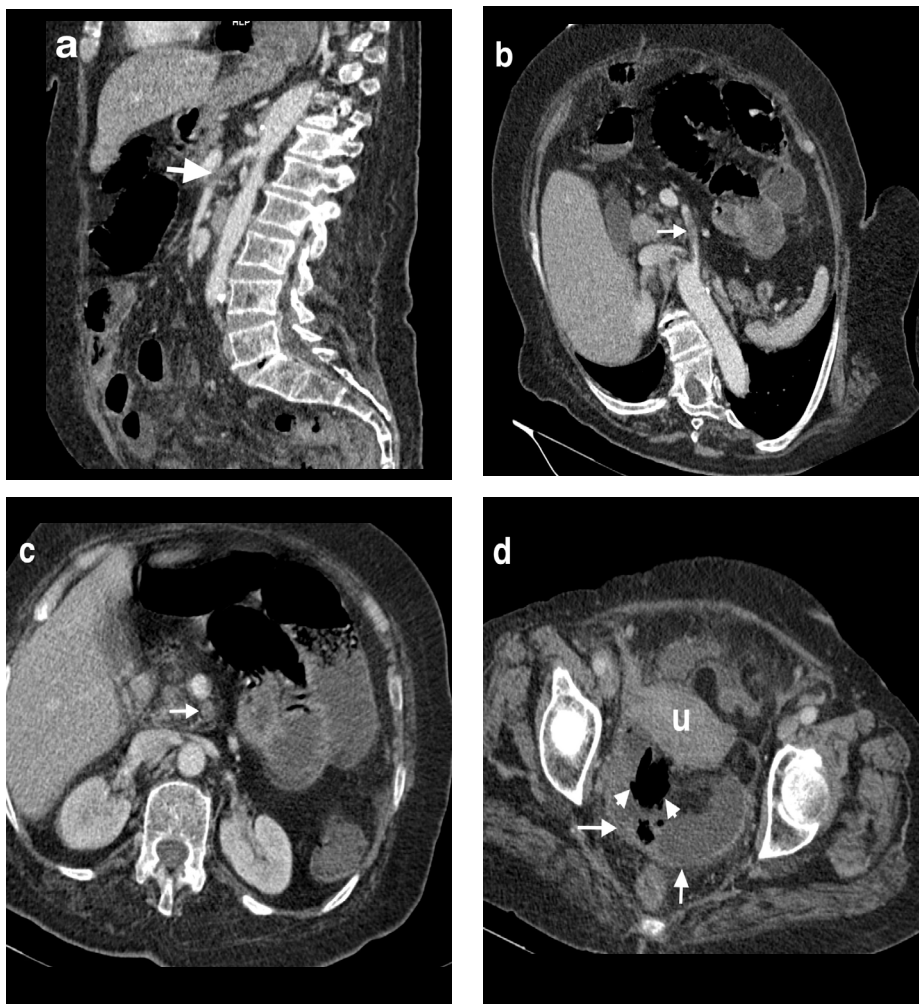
Acute superior mesenteric artery embolism. Sagittal (a), oblique reformatted (b), and axial (c) computed tomography (CT) images of a 61-year-old woman with sudden onset abdominal pain 6 days after the diagnosis of coronavirus disease-2019, revealing a hypodense filling defect (arrows) in the superior mesenteric artery lumen. Axial CT image (d) of the same patient at the pelvic level revealing hypo-enhancing segments of the ileum wall (arrows) and free intra-abdominal gas (arrowheads) behind the uterus (u), suggesting bowel wall ischemia and resultant perforation.
